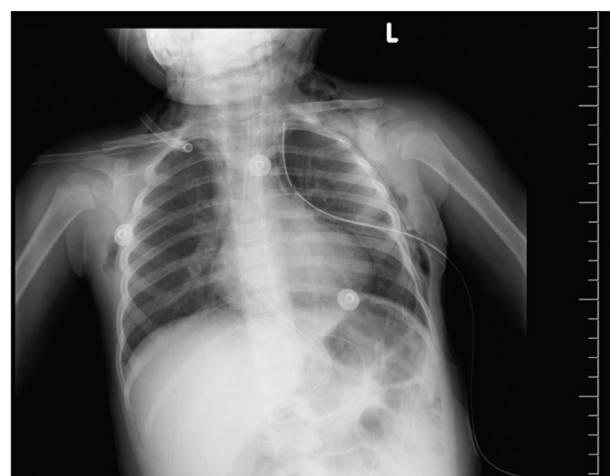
The chest radiograph that was after chest tube removal showed no pneumothorax
